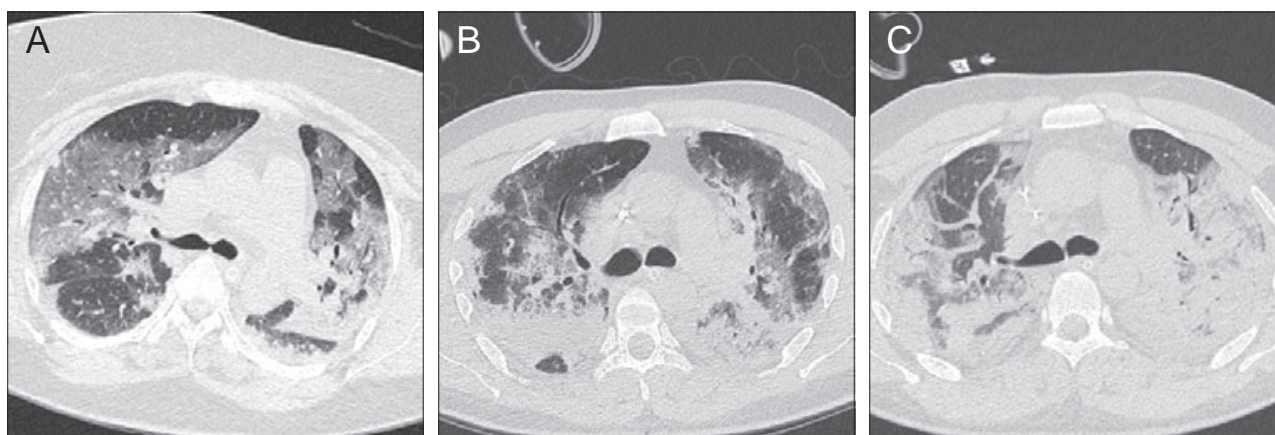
CT of the lung at the time of admission to our department. Legend: A – Case 1, B – Case 2, C – Case 3.
